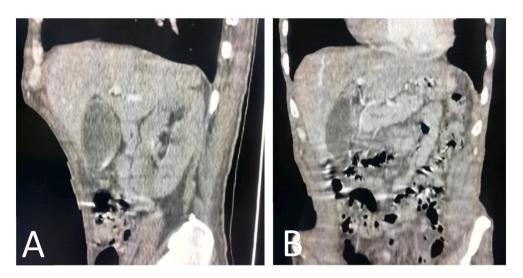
Abdominal CT scan in sagittal (A) and coronal (B) sections showing alithiasis cholecystitis.
